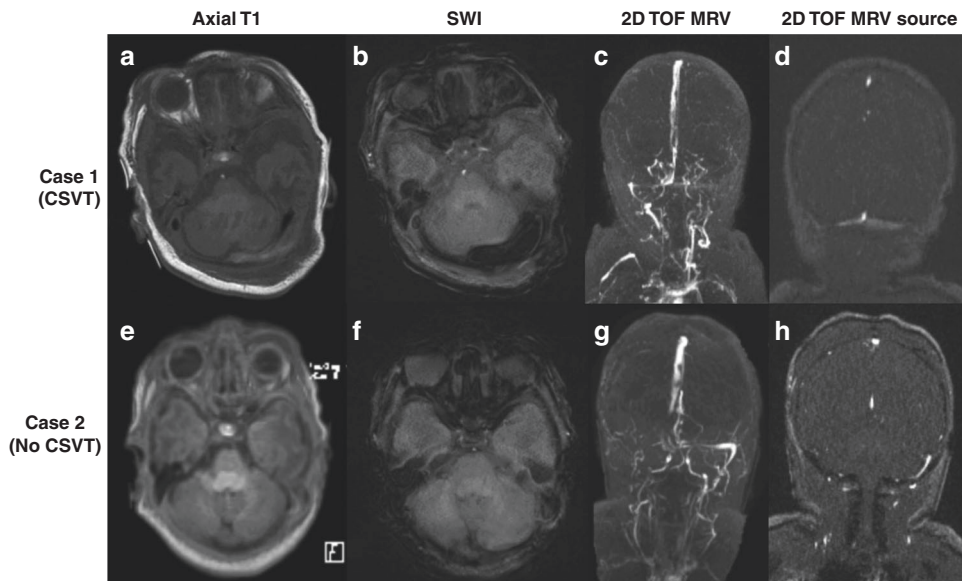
Representative MRI and MRV images for the infant with CSVT and an infant with cerebral vein asymmetry. MRI and MRV images of Case 1 (the baby diagnosed with CSVT, a–d) and Case 2 (a baby with asymmetry on MRV but no CSVT, e–h). Case 1: demonstration of linear hyperintensity on axial T1 (a) and susceptibility on SWI (b) in the region of the left transverse sinus not associated with significant asymmetry on MRV (c, d). Case 2: demonstration of the absence of flow in the right transverse and sigmoid sinuses on MRV (g, h) in the absence of clear corresponding thrombosis in T1 and SWI sequences (e, f). SWI susceptibility-weighted imaging, TOF time of flight.
